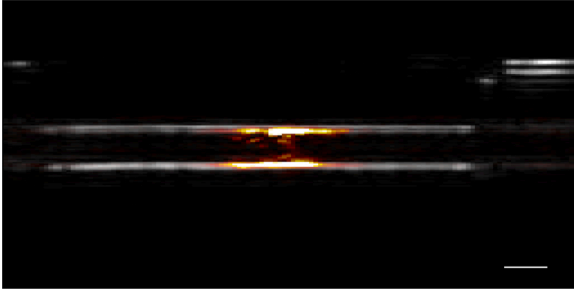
The beam-formed ultrasound (gray scale) and photoacoustic (red) image of the blank ink flowing through the tube, the scale bar is 1 mm.
